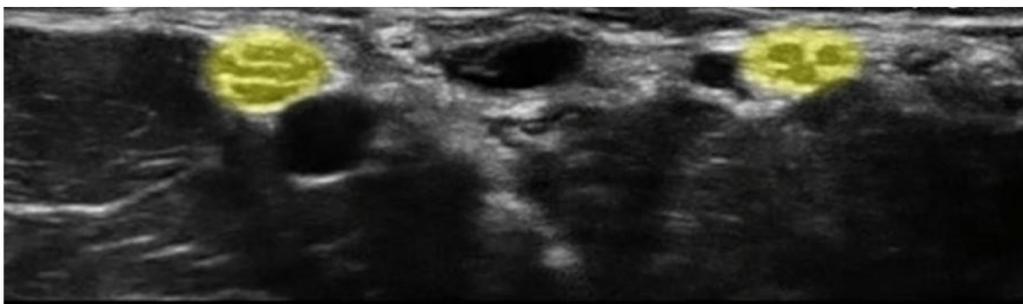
Ultrasound-guided block of the median nerve (highlighted in yellow at the top left) and the ulnar nerve (highlighted in yellow at the top right), 5 ml per site.
